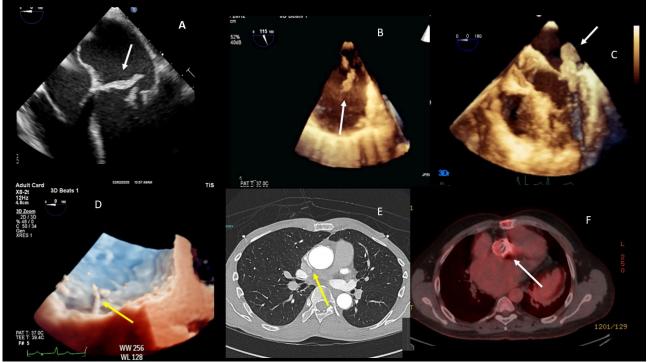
Multimodality imaging in infective endocarditis. A) 2D TEE. 4 chambers esophageal view: large vegetation attached to the base of anterior mitral leaflet in a patient affected by Staphilococcus aureus infective endocarditis; B) 3D TEE. Surgical right atrial view: large vegetation attached to the Eustachian valve; C) 3D TEE, huge vegetation attached to the posterior mitral leaflet in a patient affected by Staphilococcus aureus infective endocarditis; D) 3D TEE, surgical left atrial view, large vegetation attached to the atrial surface of mechanical prosthetic mitral valve; E) cardiac CT, short axis view at the level of the aorta showing a small pseudoaneurysm (arrow) posterior to the aortic root; F) fluorodeoxyglucose uptake in the aortic wall at combined positron emission tomography /computed tomography corresponding to infectious endocarditis. TEE: transesophageal echocardiography.
